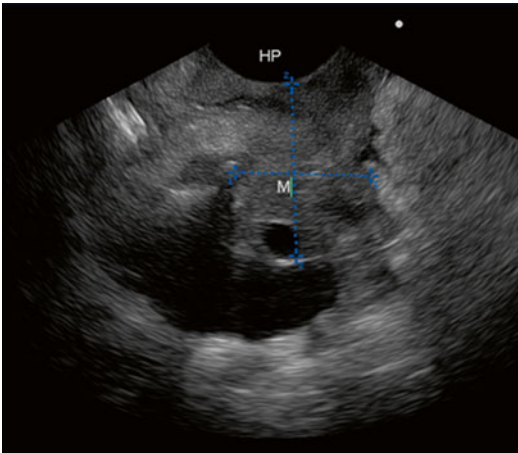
The irregular relationship between the solid mass of pancreatic adenocarcinoma (M) and the portal vein is endosonographically demonstrated
